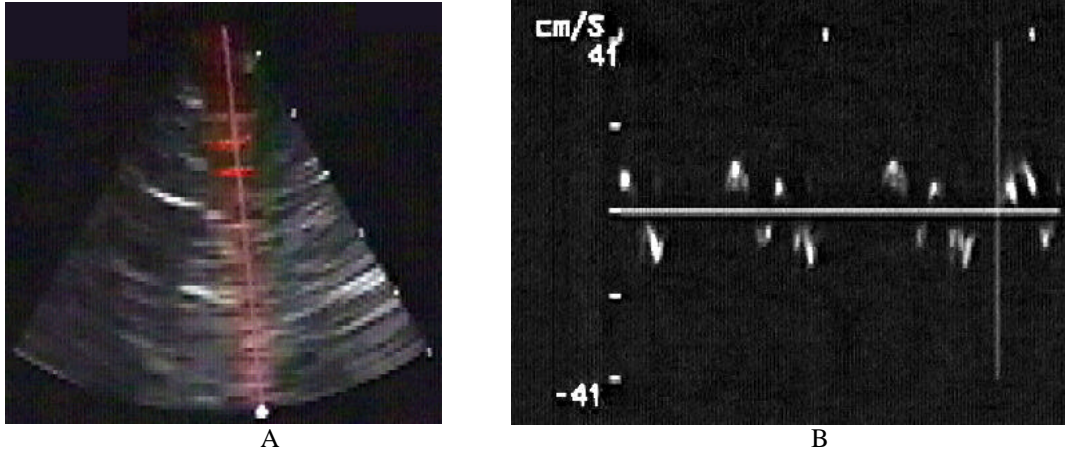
Spectral Doppler image showing wall motion in the aorta. Figure 11A shows the 6 cm deep B-scan and the location of the Spectral marker in red. Figure 11B shows the resulting Spectral Doppler.
